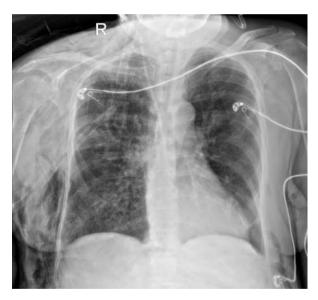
Chest X-ray AP view showing the position of the internal jugler line
